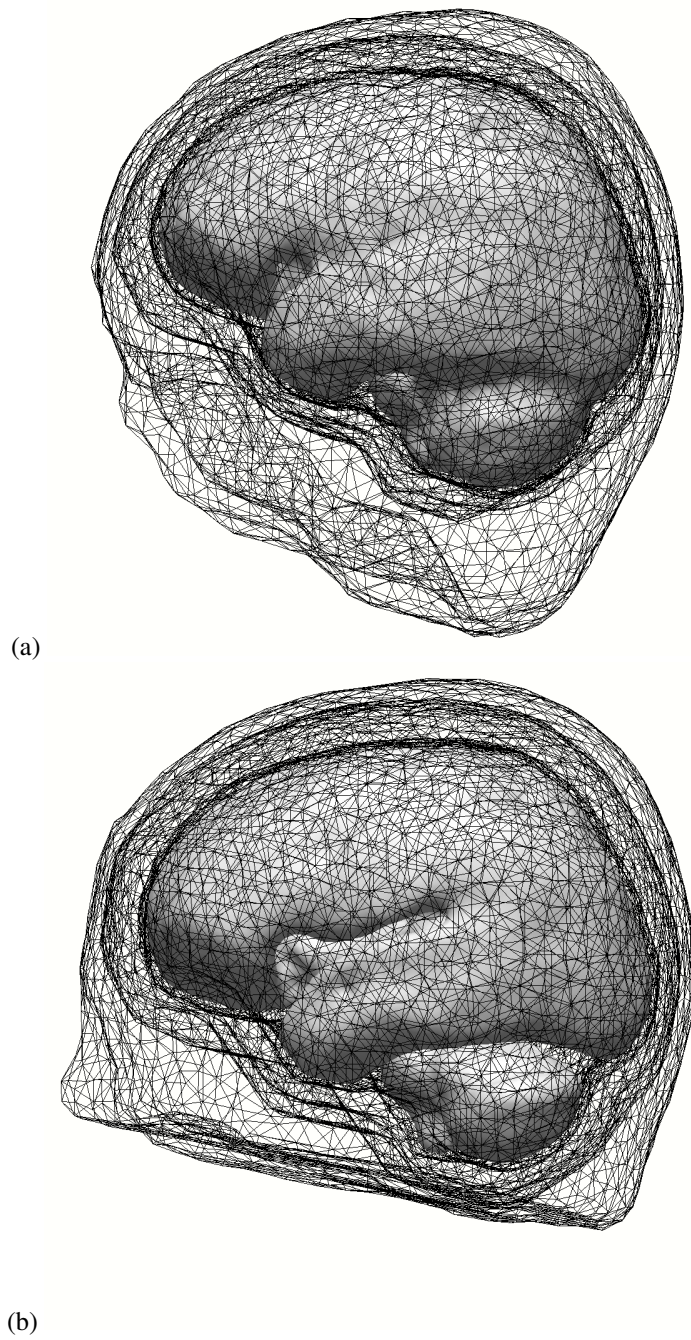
Realistically shaped BEM head models enclosing the cortical surface for a) the MRI-62-A dataset and b) the ICBM-152-A dataset.
